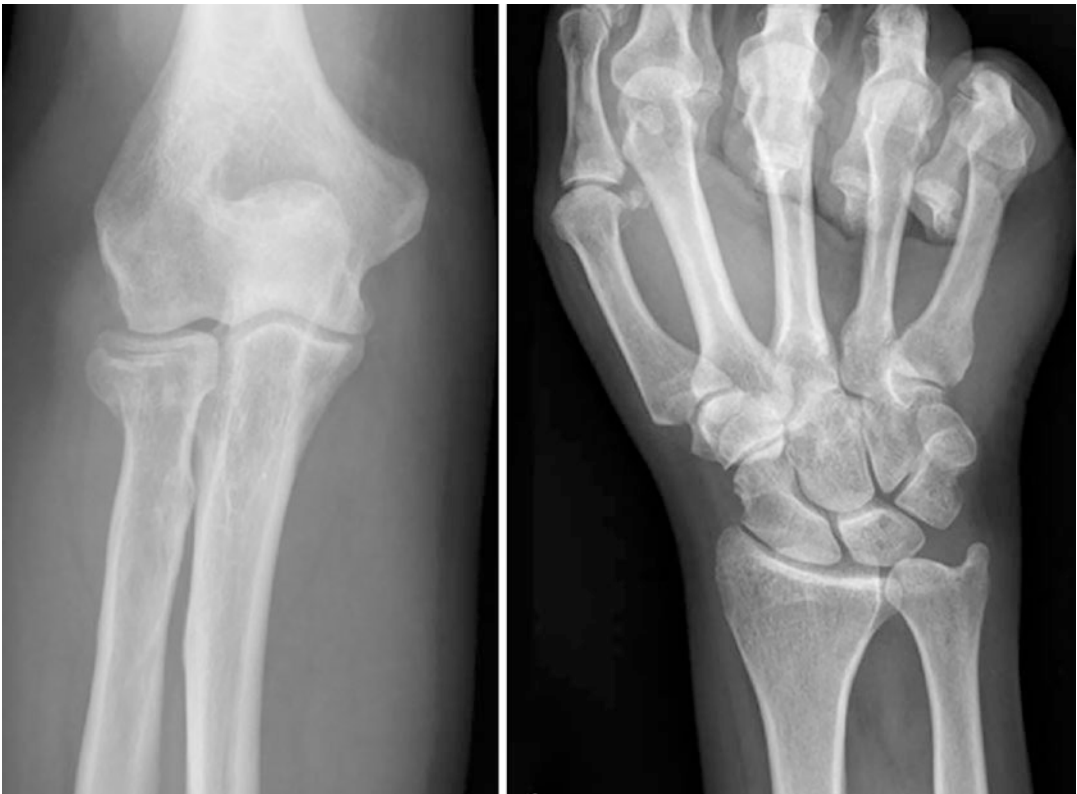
AP elbow and wrist radiographs demonstrating a radial head fracture (left) and longitudinal instability resulting in ulnar-positive variance as seen in Essex-Lopresti injuries
